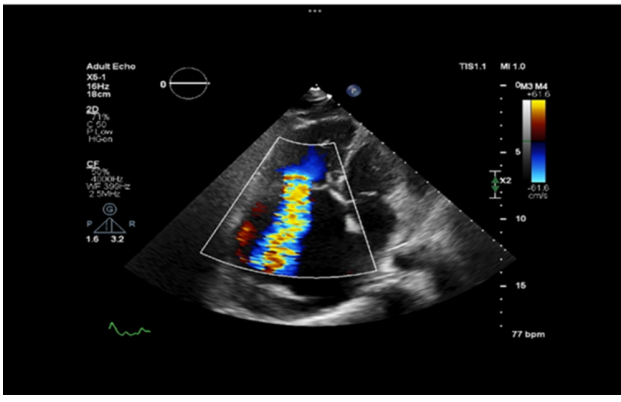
Transthoracic Echocardiography Image Showing Severe Tricuspid Stenosis with Severe Tricuspid Regurgitation.
